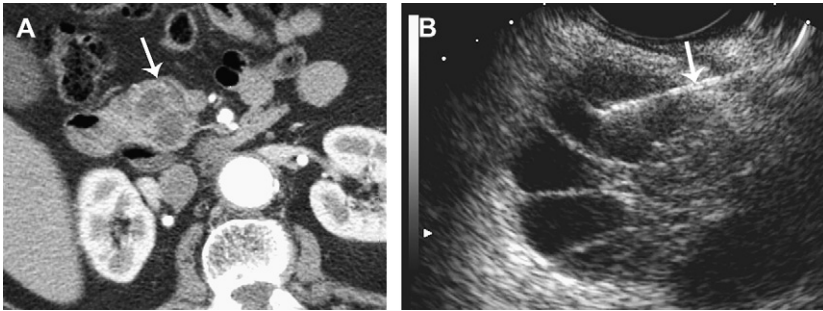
Seventy-three-year-old man who has serous microcystic adenoma discovered on CT evaluation of an abdominal aortic aneurysm. (A) Contrast-enhanced CT shows a multicystic mass (arrow) in the pancreatic head. (B) EUS shows multiple small cystic spaces separated by thin septa. A fine needle aspiration needle (arrow) was inserted and yielded thin fluid with glycogen-rich cuboidal cells.
